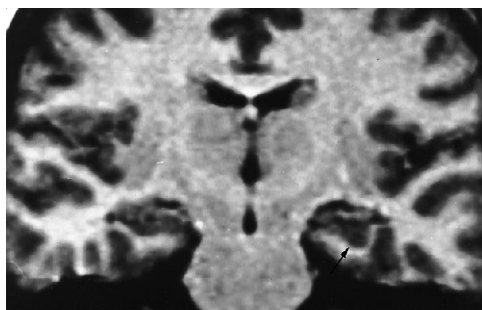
Patient 8: focal abnormality of the subiculum. Oblique coronal T1-weighted section: at the level of the junction between the left subiculum and Ammon's horn, the gray matter of the subiculum was thickened and protruded into the white matter of the underlying parahippocampal gyrus (arrow). The ipsilateral hippocampal formation was atrophic. No hyperintensity was visible on T2-weighted images (not shown).
